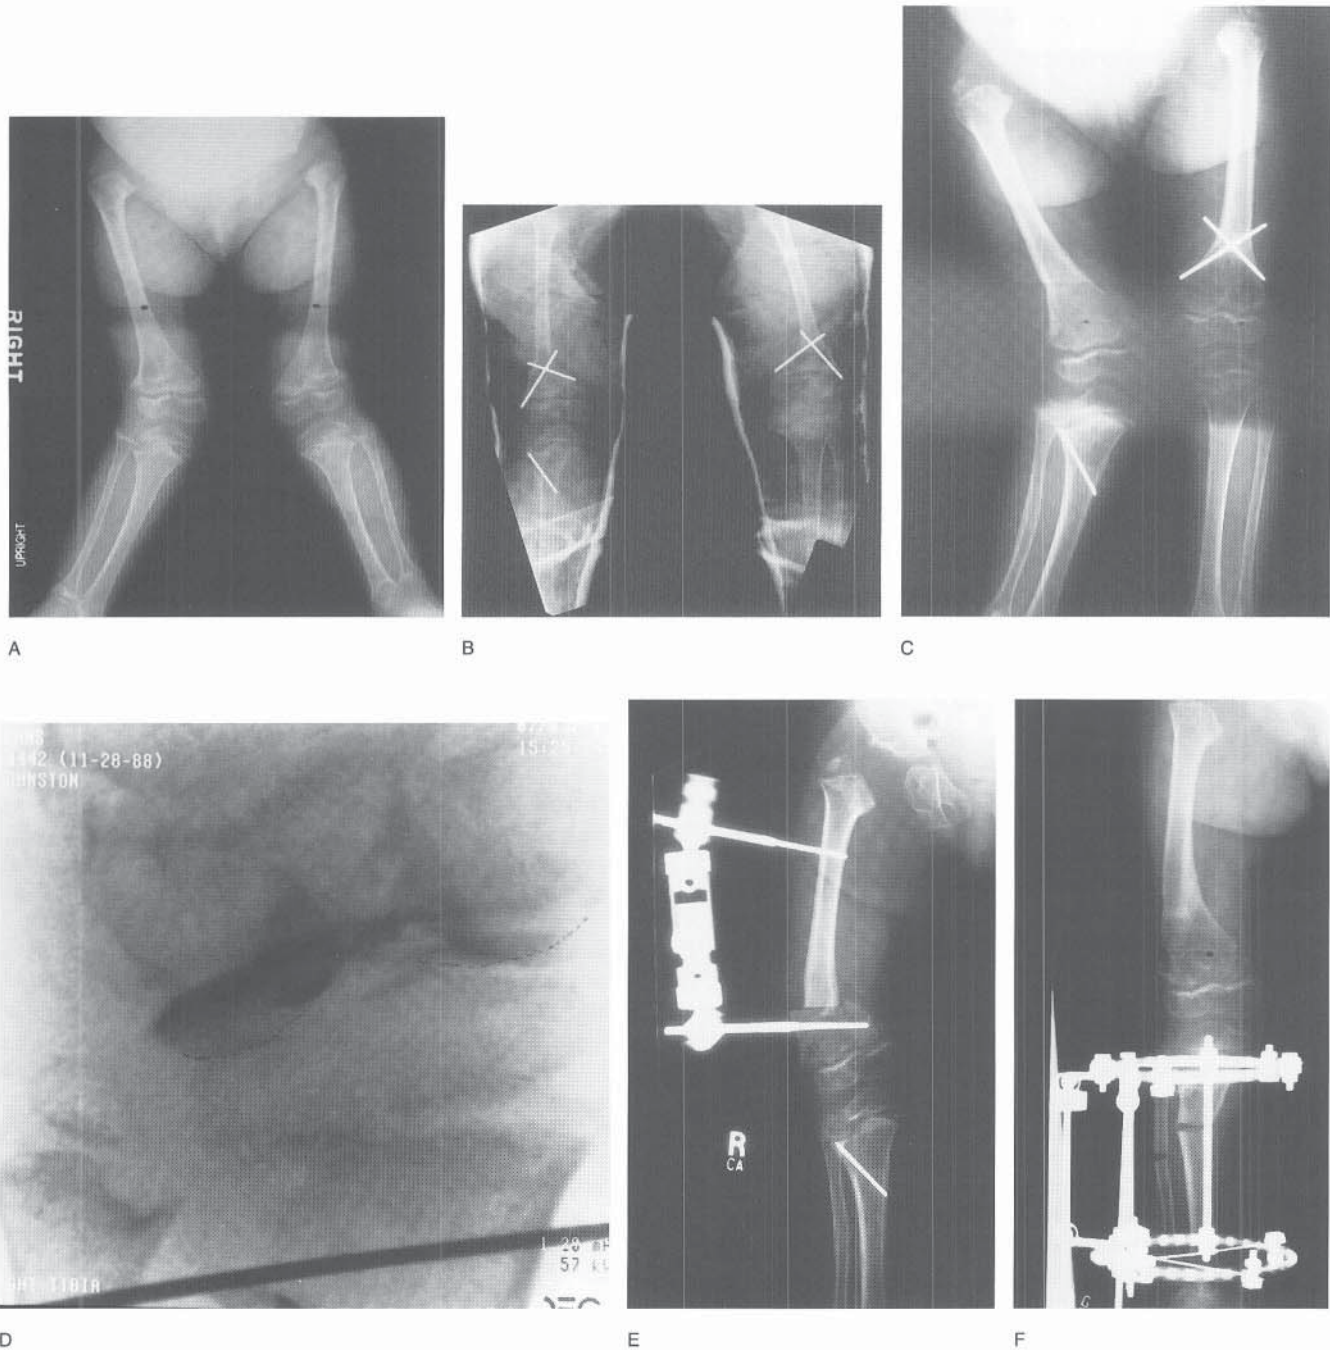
A, Radiographs of a 6-year-old girl with SED congenita. B, She underwent correction by multiple osteotomies. C, Marked recurrence on the right 1 year postoperatively. D, Intraoperative arthrogram demonstrating valgus deformation within the intra-articular surfaces themselves. E and F, Because of the need to adjust alignment postoperatively in the weightbearing position, correction of the femoral and tibial deformities was accomplished with external fixation.
